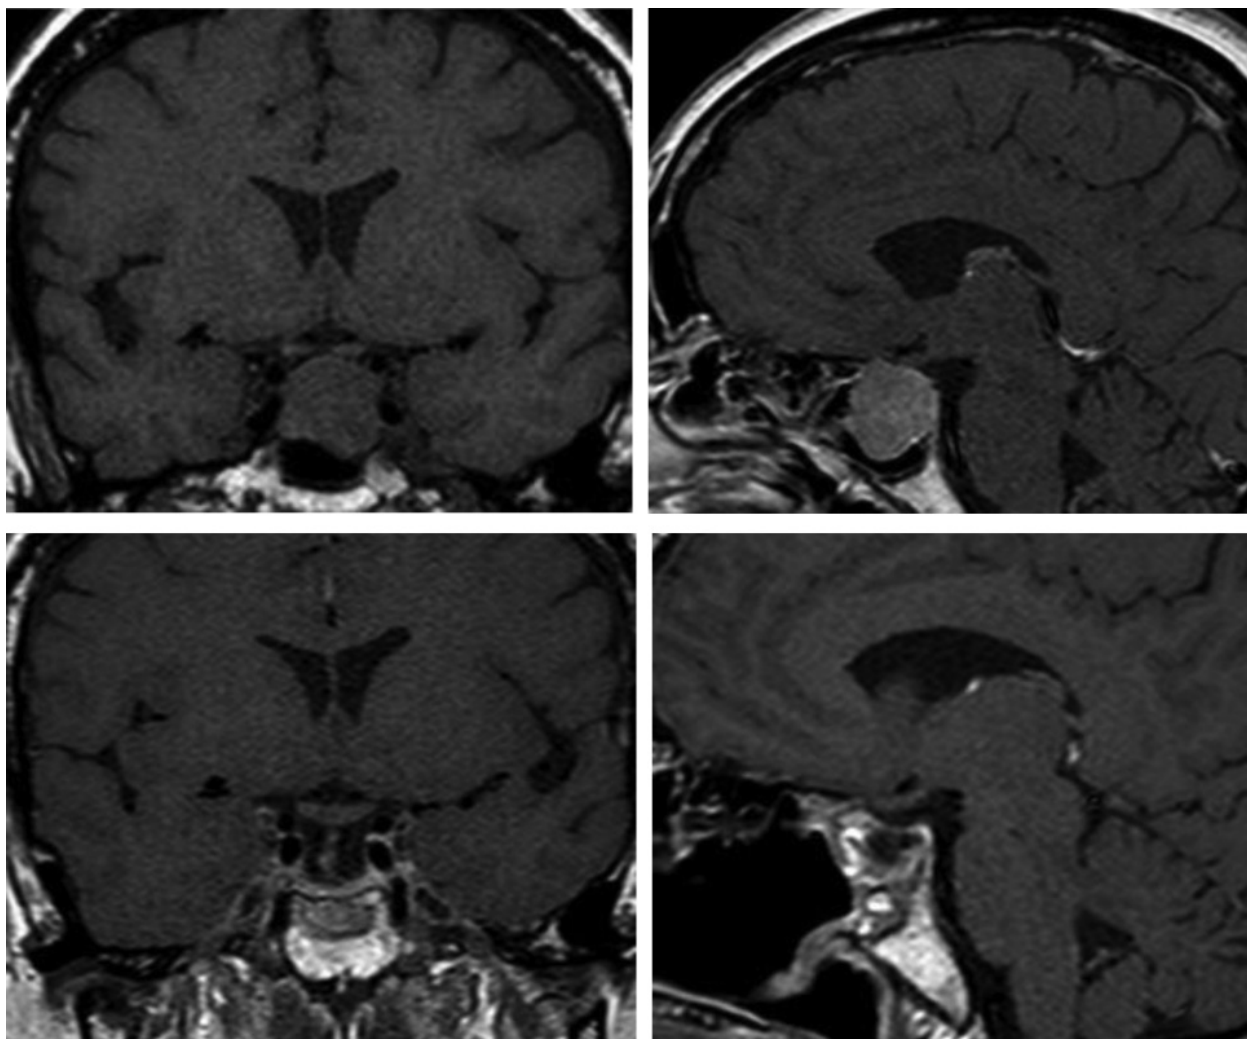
MRI of the brain of a female patient who underwent total excision of endosuprasellar hormonally inactive pituitary adenoma. (A) Preoperative coronal view. (B) Preoperative sagittal view. (C) Postoperative coronal view. (D) Postoperative coronal view.
